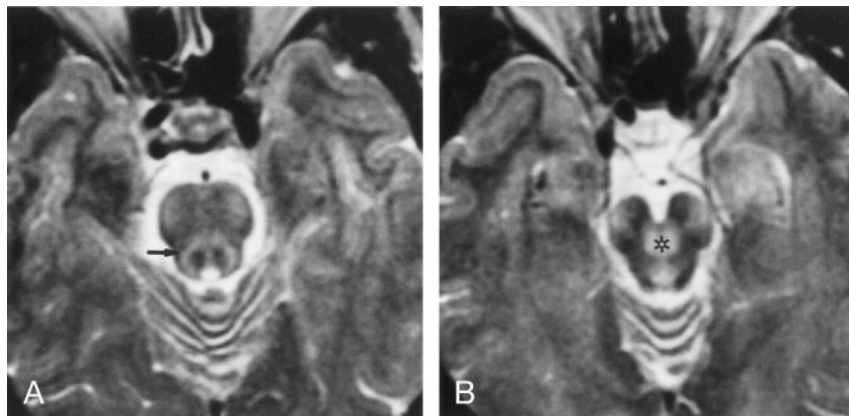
Axial SE T2-weighted images show mild hyperintensity of the corticospinal and corticopontine tracts in the cerebral peduncles and basis pontis.
